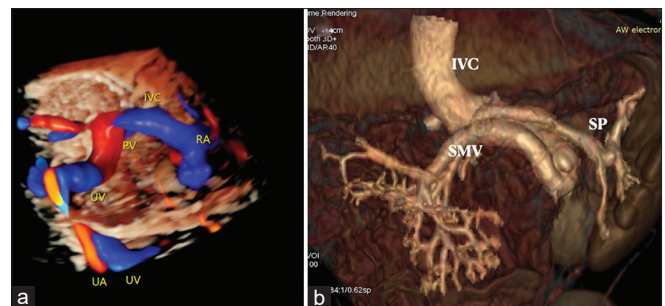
(a) Three-dimensional color flow volume rendered image of a fetus showing direct drainage of umbilical vein to inferior vena cava (IVC), (b) computed tomography angiogram of the same patient showing drainage of portal vein into IVC through the fistulous tract. UV: umbilical vein, PV: portal vein, RA: right atrium, IVC: inferior vena cava, SMV: superior mesenteric vein, SP: spleen, UA: umbilical artery
